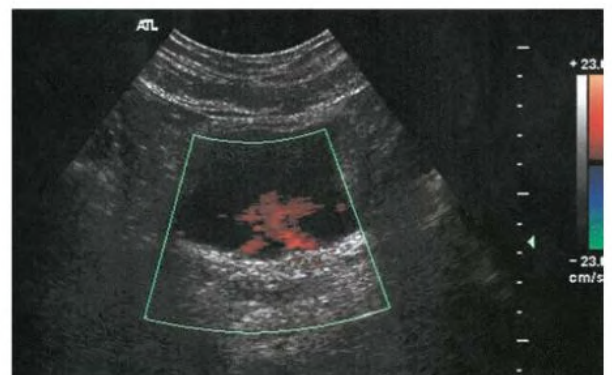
Bilateral Ureteral Jets in Bladder. Color Doppler ultrasound study detects this normal appearance.
